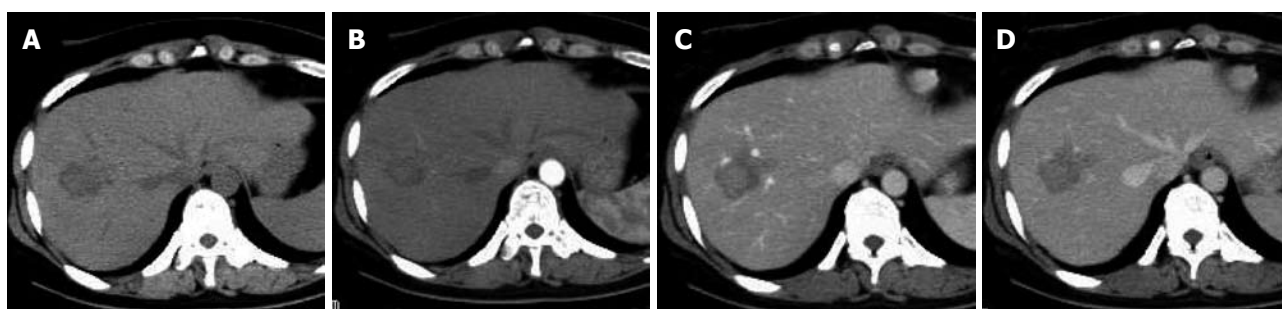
Computed tomography (CT) in March 2007. A: Plain; B: Arterial phase; C: Portal phase; D: Delayed phase.
